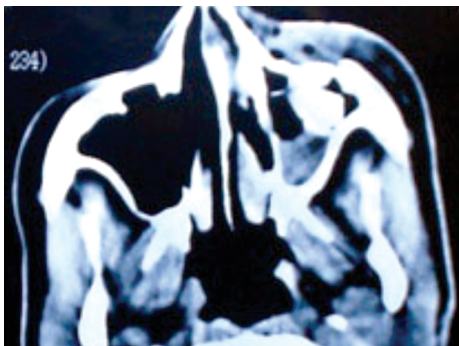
Preop. CT scan axial view.
